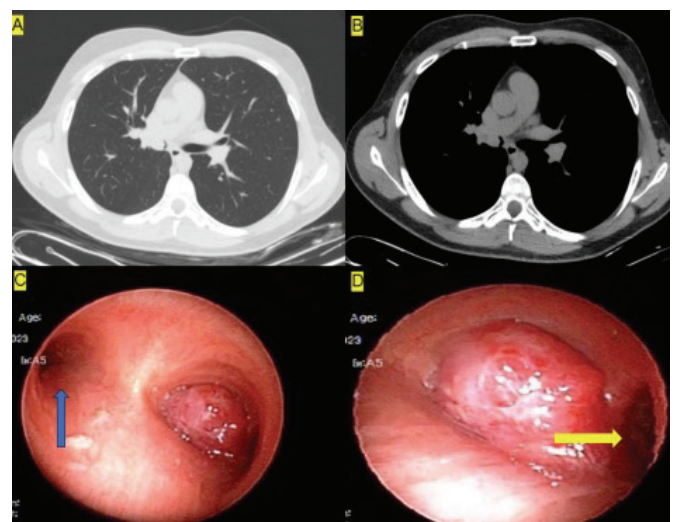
CT bronchoscopy and images of a tumor localized in the intermediate bronchus A: CT parenchymal section image of the lesion in the intermediate bronchus localization. B: Mediastinum section, C: FOB image, blue arrow, upper lobe entrance, lesion at the intermediate bronchus entrance, D: FOB image, yellow arrow, middle lobe.
